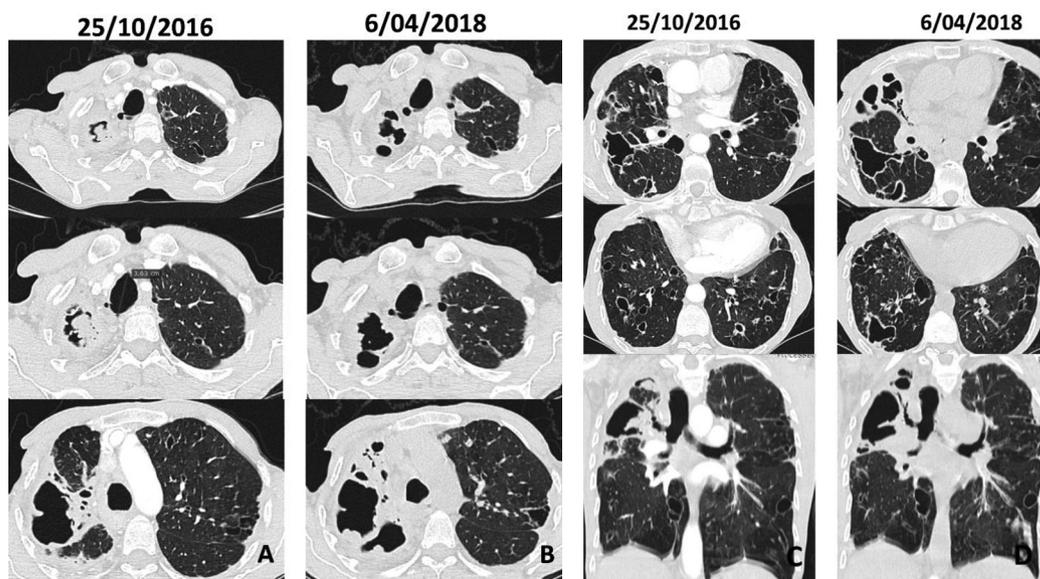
HRCT, lung window, prone position, five transversal images at different anatomical levels and coronal reconstruction (October 2016) demonstrating the spread of bronchiectasis (tubular, varicose and cystic) in all lobes and multiple large, irregular, thick-walled cavities with intracavitary masses (*fungus ball*) and pleural thickening. The mass is with air-crescent sign but no fluid level. Note tracheal enlargement and a tracheal diverticulum. (B, D) HRCT images taken 18 months later, patient being without any antifungal treatment. Transversal sections and coronal reconstruction at the same anatomical levels as in 2016 showing completely destroyed right upper lobe, an increase in size of the cavities and pleural thickness. New areas of consolidation close to cavitary lesions were observed and no intracavitary masses. Both lungs show distortion features, severe cystic bronchiectasis and progression of the disease.
